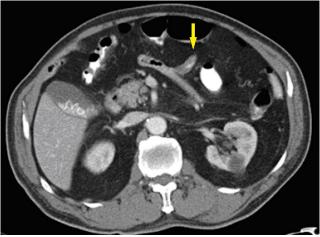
CT of the abdomen and pelvis shows left-sided appendix with irregular thickening of the appendix wall.
